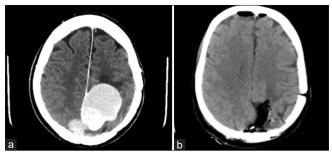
(a) The lesion on an axial section in the late phase of the preoperative computed tomography (CT) scan with contrast matter; (b) Postoperative CT head scan showing the subtotal resection of the lesion.
